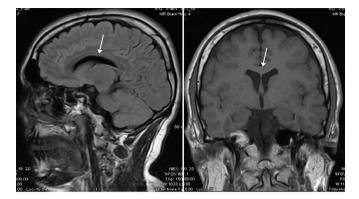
MRI brain of patient 1. MRI brain with intact corpus callosum.
